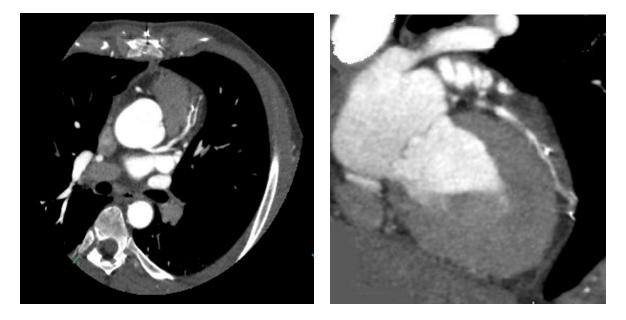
(a & b): postopertive CT angiogram showing release of LAD
